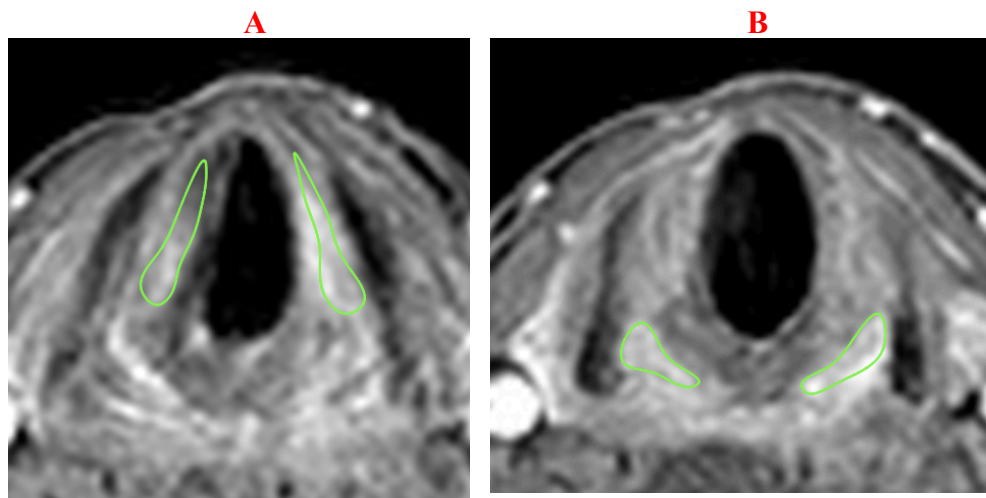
Post-contrast T1 weighted image from DCE MRI. The image demonstrates enhancement within the: A) Thyroarytenoid (TA) and B) Posterior cricoarytenoid (PCA) muscles. Regions of interest outlined in green lines within the TA and PCA are used to derive time versus signal intensity curve (below) from which quantitative metrics (SoE, ME, AUC-1) can be derived.
